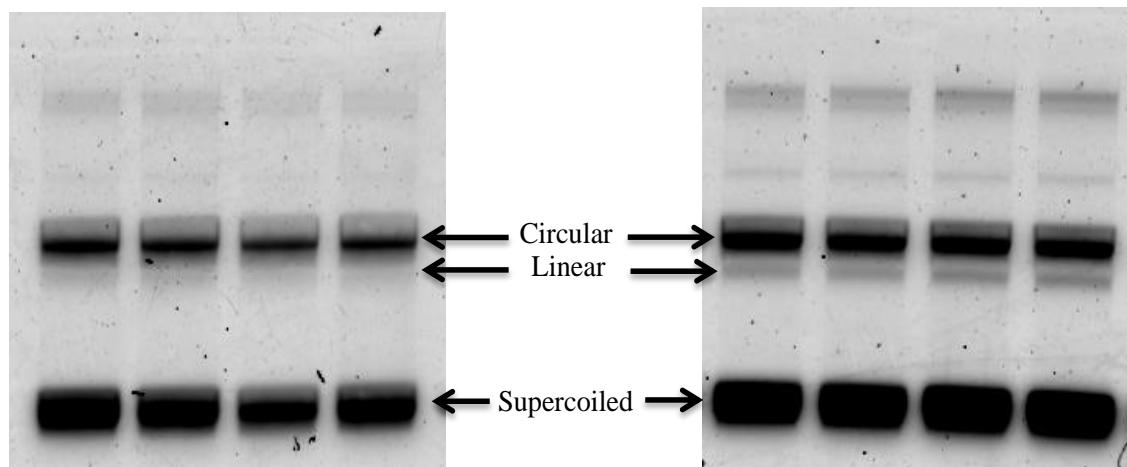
Agarose gel electrophoresis analysis of plasmid DNA films deposited on glass (left) and tantalum (right) substrates irradiated with 1.5 keV X-rays at SATP conditions and under 20% of humidity.
